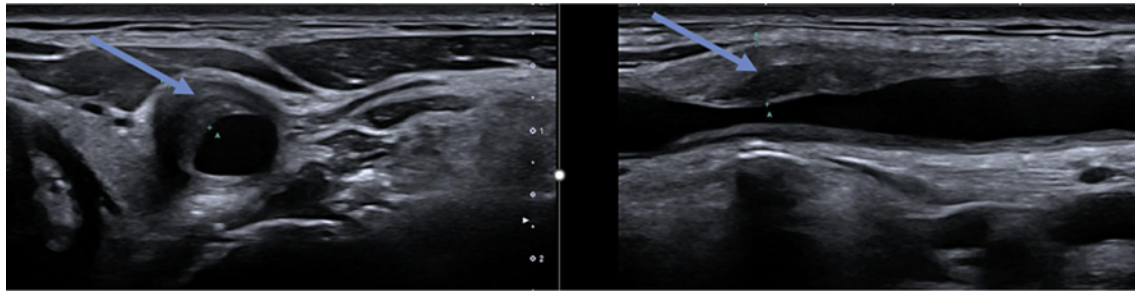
Ultrasound of left carotid artery with thickening of vessel walls up to a maximum of 4.45 mm.
